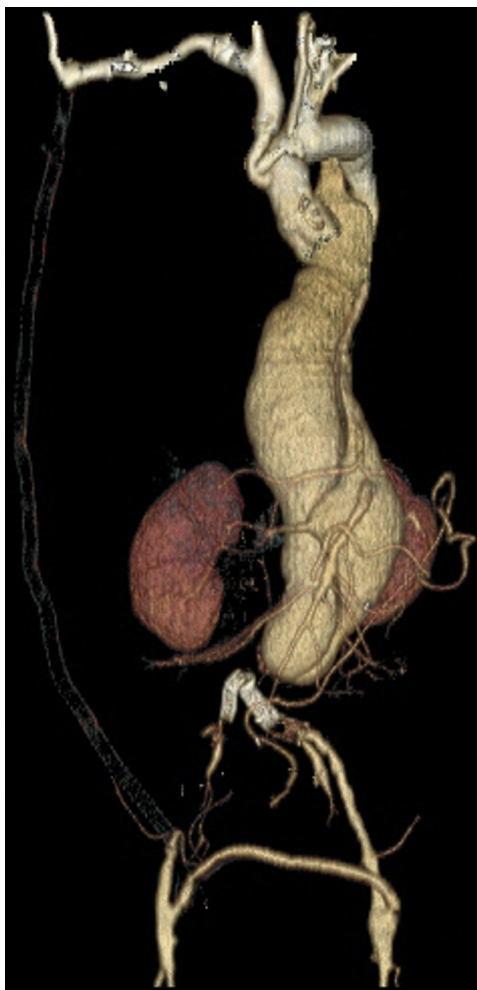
Preoperative computed tomography scan with volume rendered reconstruction of the extent II thoracoabdominal aortic aneurysm (TAAA).
